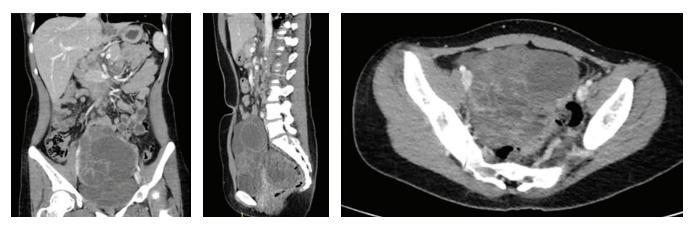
Contrast-enhanced CT scan of the whole abdomen showing the large lobulated complex pelvic mass with mass effect to the adjacent structures.
